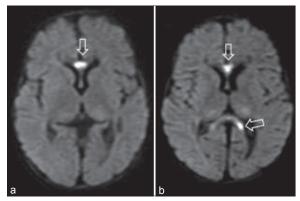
(a and b) Magnetic resonance imaging findings showing features suggestive of progressive cavitating leukoencephalopathy. Corpus callosal lesions showed restricted diffusion and low apparent diffusion coefficient values probably due to active demyelination in these regions (open arrows). Also noted was that, there was no significant diffusion restriction of lesions in the periventricular area or in the centrum semiovale and there was sparing of subcortical U fibers. The basal ganglia, thalami, brainstem, cerebellum and upper cervical cord were uninvolved
